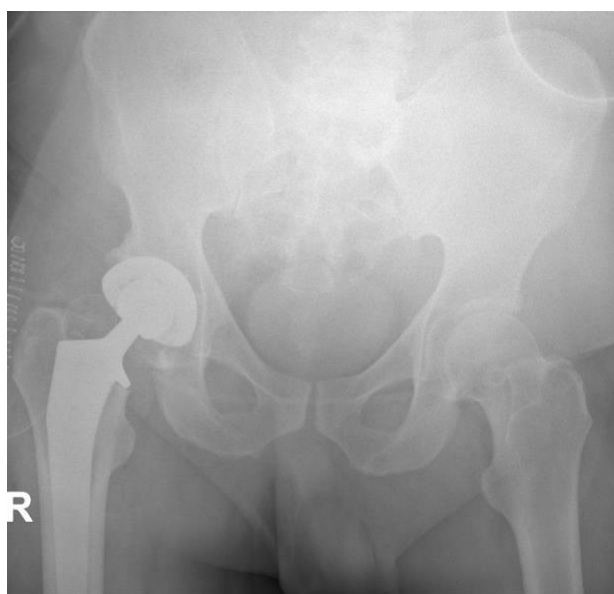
Post-operative X-ray after the primary THR showing the primary THR in good position.
